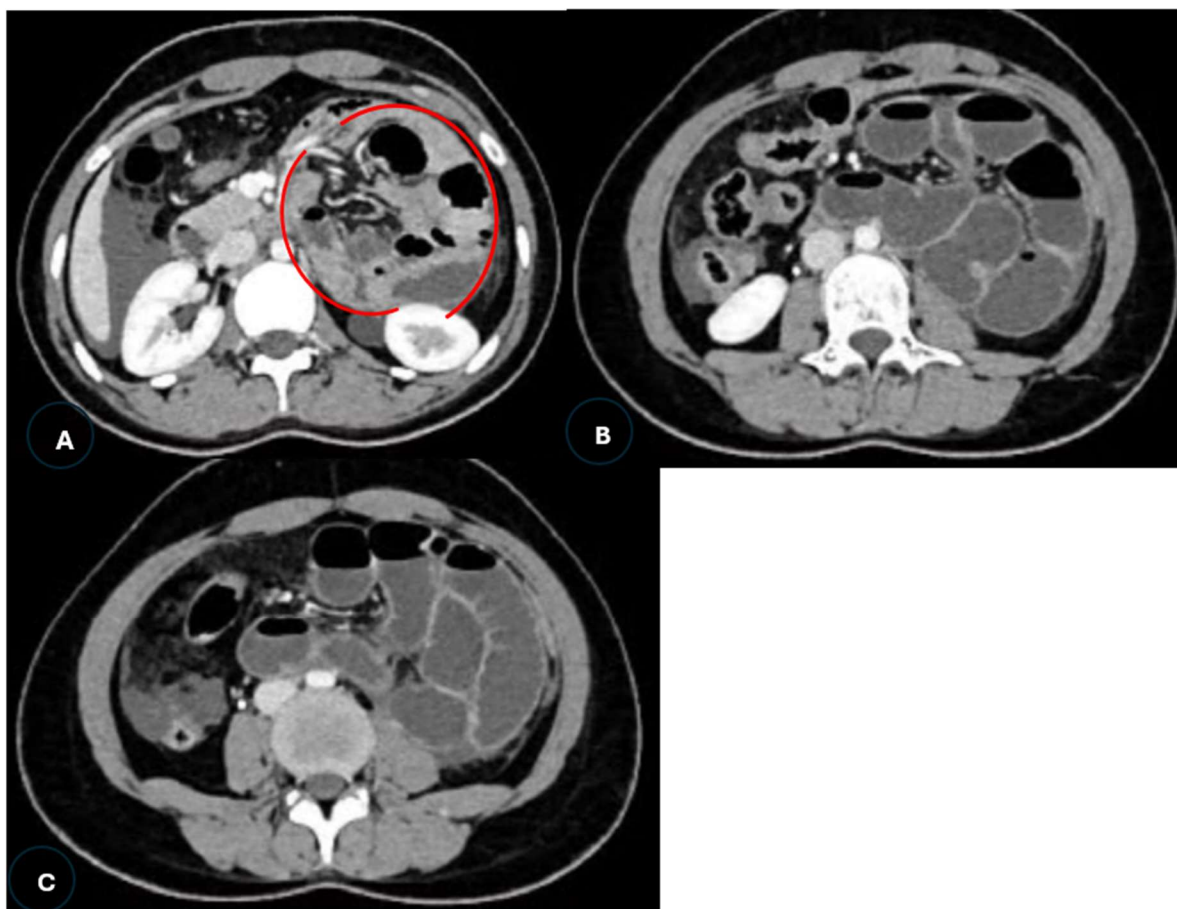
Figure A-Contrast enhanced CT showing left paraduodenal hernia -majority of small bowel inside
